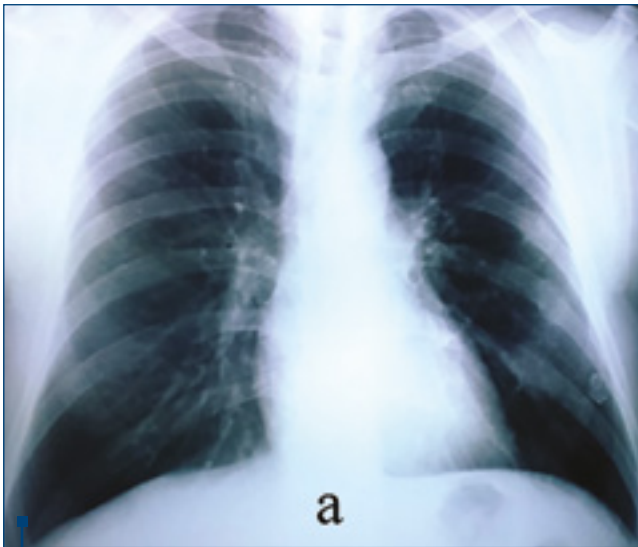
Chest X-rays. (a) Before admission to hospital. (b) At hospital admission showing bilateral diffuse infiltrates and cysts in the mid and upper zones of both lungs.
